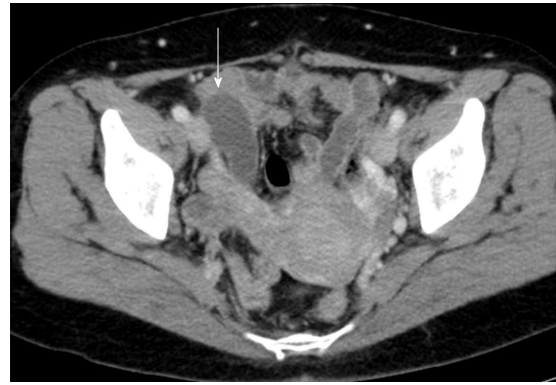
Computed tomography. The arrow shows a 55 mm × 25 mm, low-density and no-contrast lesion at the appendix.
